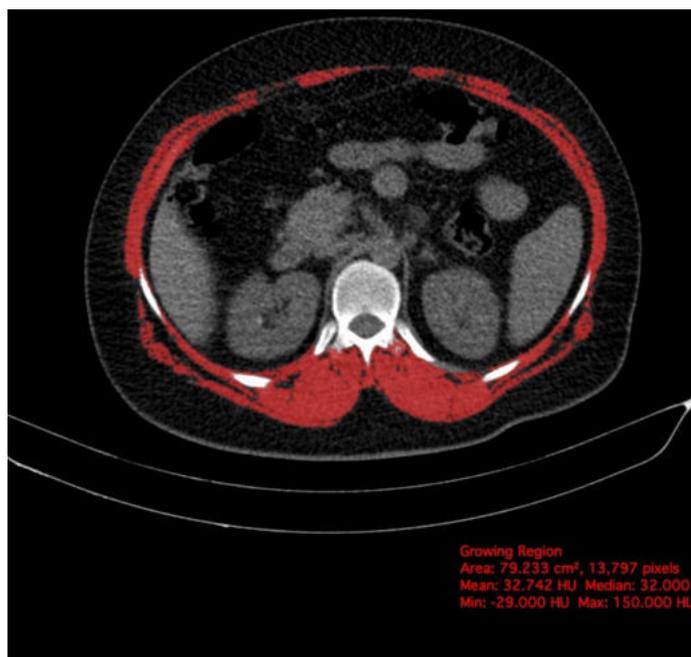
T12-SMA measurement on chest CT image at the T12 vertebra level. Red zone indicating the cross-sectional skeletal muscle area identified using a threshold of -29 to +150 HU (T12-SMA 79.23 cm², T12-SMI 30.07 cm²/m²).
